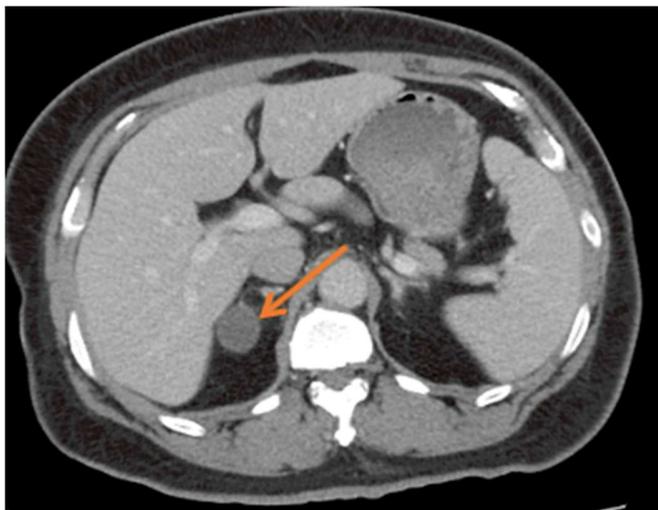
CT scan showed a 3cm right adrenal mass with homogenous appearance
